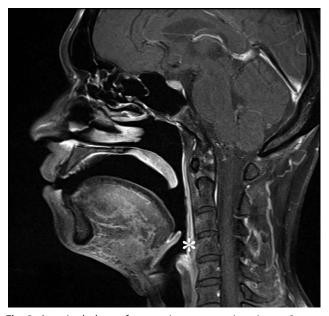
A sagittal plane of magnetic resonance imaging at 2 years postoperatively. Descent of epiglottis is not observed, and the space between epiglottis and arytenoid is wide enough to breathe without tracheostomy (*).
